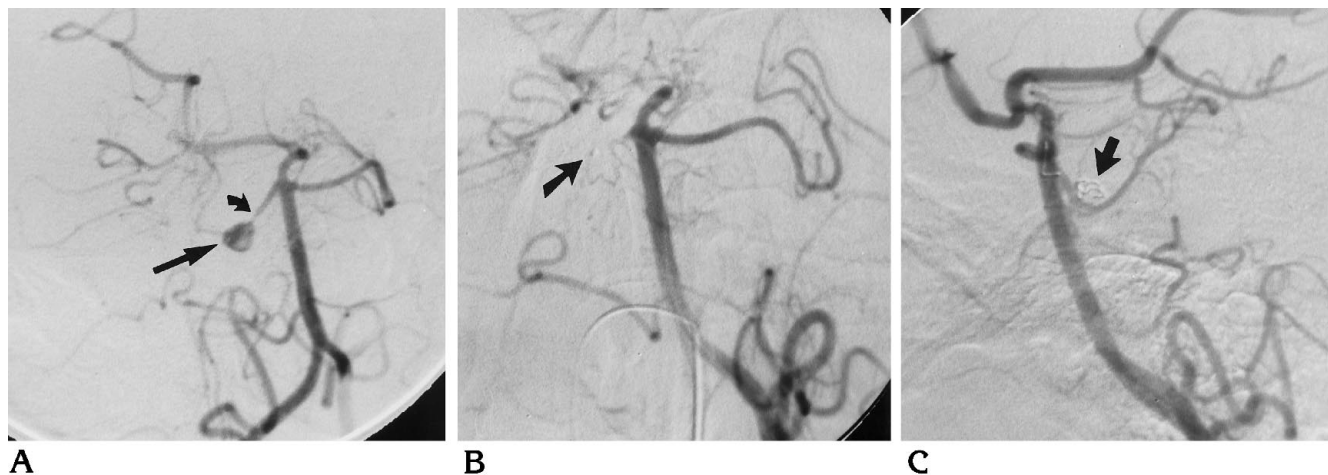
Forty-year-old man with subarachnoid hemorrhage on CT scans.
